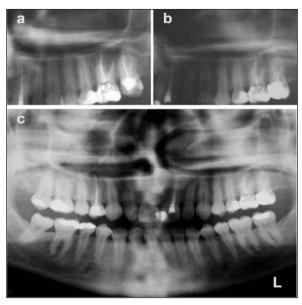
Radiographs taken after operation (a: 3. b: 6. c: 12. months).
